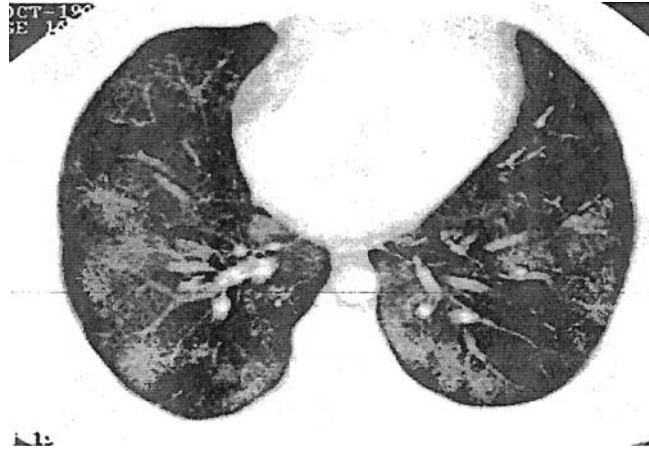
Pulmonary alveolar proteinosis (PAP). CT scan demonstrates multiple foci of ground glass opacities, interspersed with normal appearing lung parenchyma. Open lung biopsy demonstrated classic features of PAP. (Reproduced with permission. From Ref. 85.)
